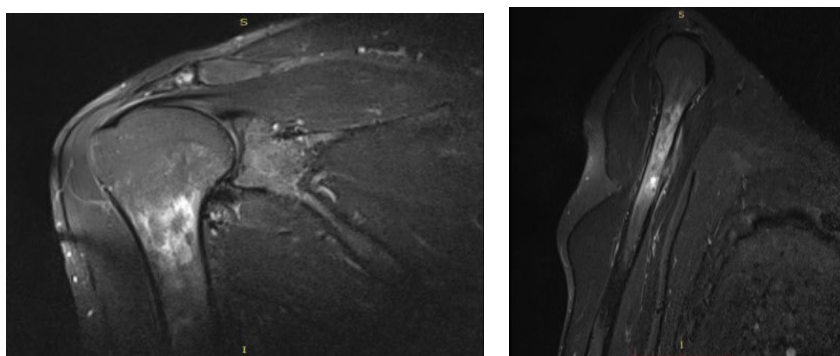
Right shoulder (left) and right upper limb (right) MRI with contrast – diffuse bone marrow edema in the proximal third of the right humeral diaphysis, fusiform thickening of the antero-inferior cortex, with surrounding reactive sclerosis and a small central bone nidus
